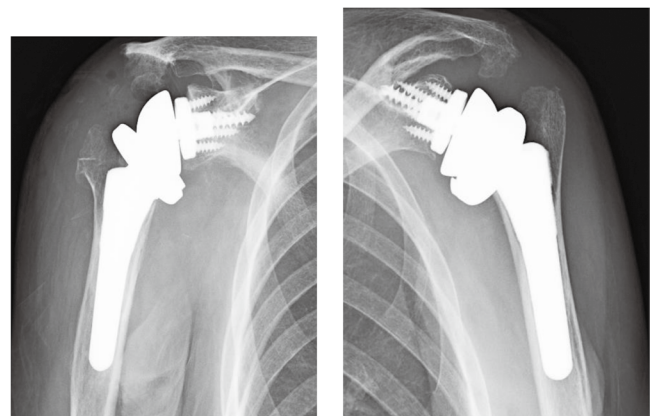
A postoperative plain X-ray of case 2.
